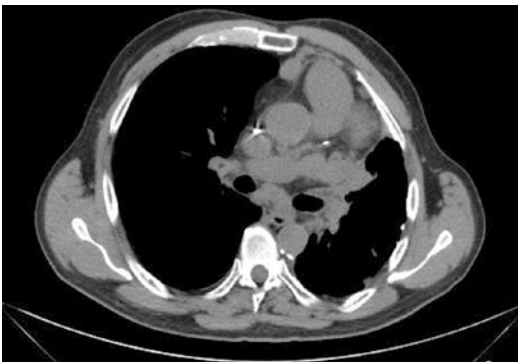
Midthoracic axial CT section demonstrating subcarinal conglomerate nodal mass (arrows) and perivascular lymphadenopathy (arrowhead)
